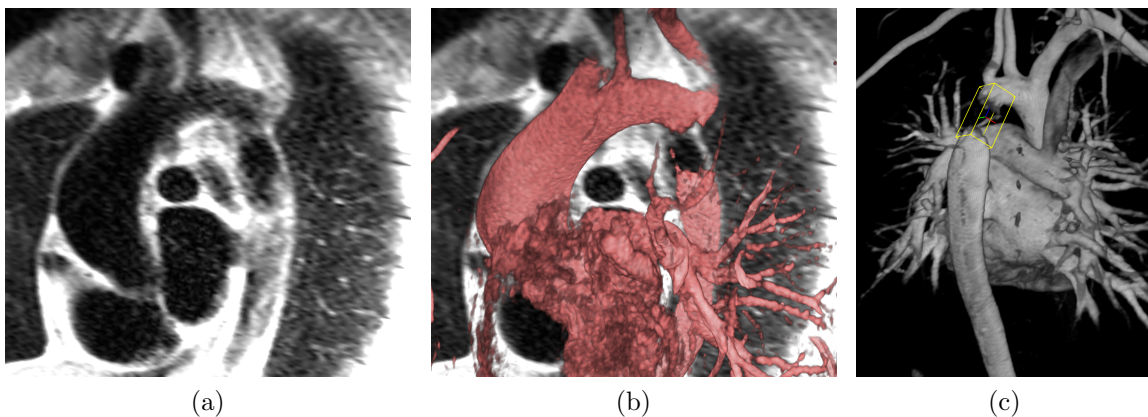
Effects of implanted metallic stent on MR image quality. Left: 2D spin-echo MR image, note that the whole descending aortic lumen is continuously visible. Middle: In a 3D cardiac MR volume (typical to our investigation) of the same region (red volume), the metallic stent produces a signal “drop-out” artifact rendering the lumen visually missing. Right: Bounding box of a stent region θ_{St} .
